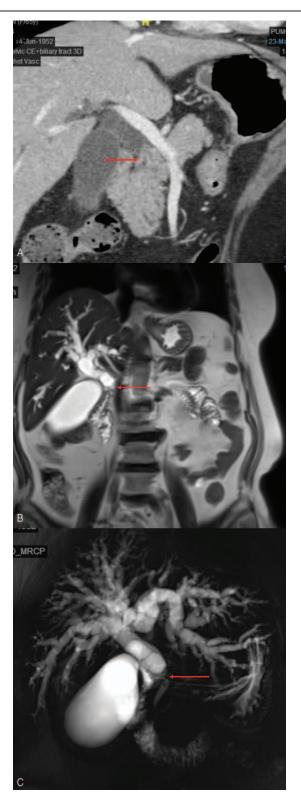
The preoperative images of patients with sarcomatous choledochal carcinoma (SCC) with typical changes. (A) The computed tomography image of a patient with SCC showed a hypodense lesion in common bile duct (CBD) (arrow). (B) The magnetic resonance imaging image of a patient with SCC showed multiple uneven segmental stenosis and dilation of CBD on T1 weighted image (arrow). (C) The magnetic resonanced cholangio-pancreato-graphy image of a patient with SCC showed multiple high-intensity signals in CBD (arrow).
